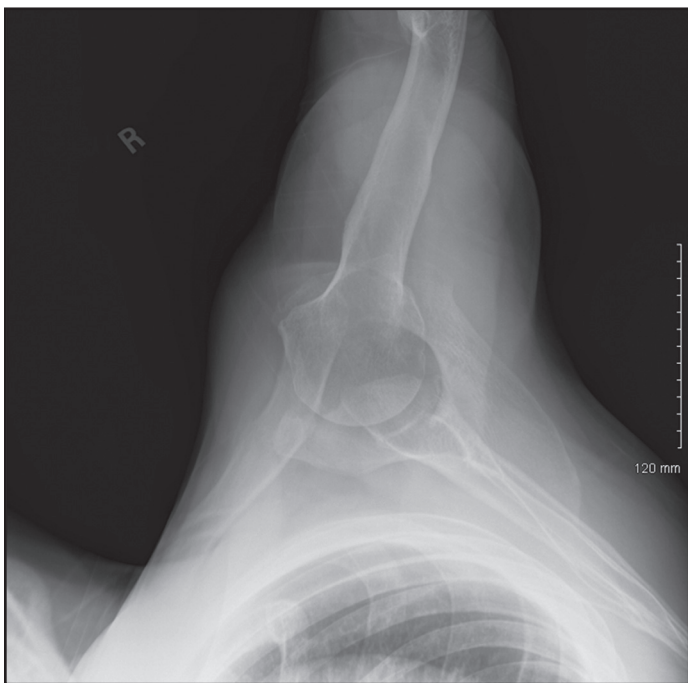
Axillary view radiograph of the subject's right shoulder, used to examine the positional relationship of the humeral head and glenoid fossa, which was intact in this case.
